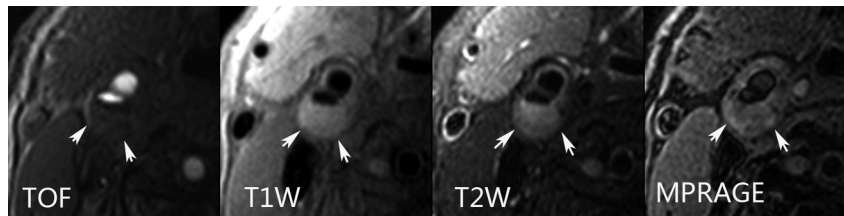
An atherosclerotic plaque with a large LRNC was found in the right internal carotid artery of a 65-year-old male patient who had ipsilateral first-time acute ischemic stroke. The plaque exhibits an intact surface and typical signal-intensity patterns of LRNC (arrows) on TOF, T1-weighted, and T2-weighted images. No high signal intensity was present on the MPRAGE image representing IPH.
